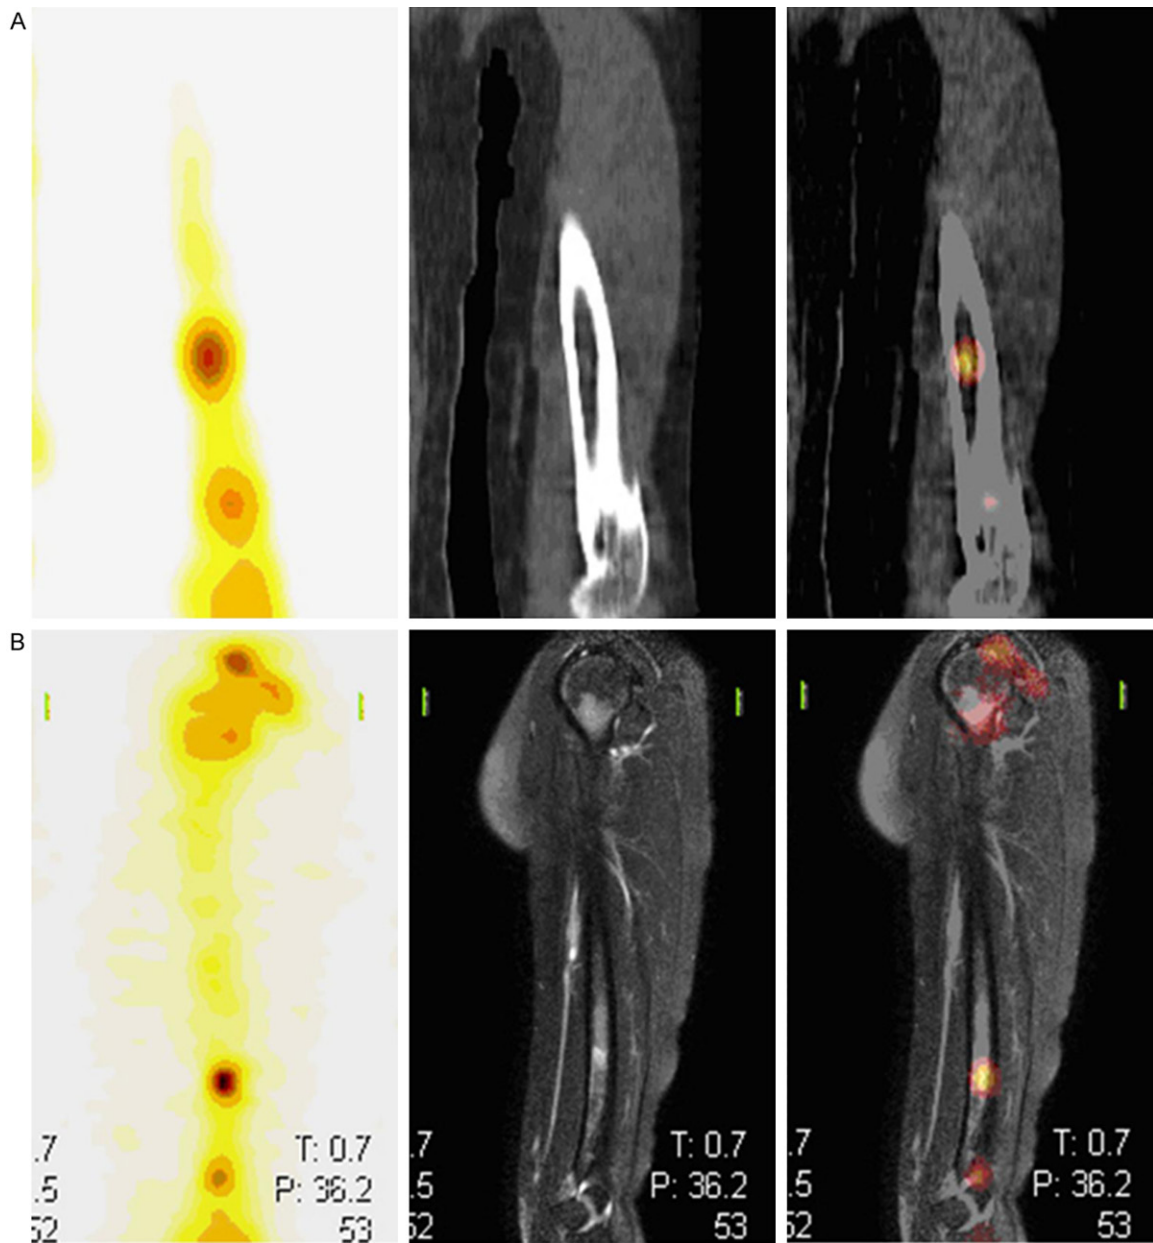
SPECT/CT and SPECT/MRI images in humerus. A. SPECT/CT image in humerus. B. SPECT/MRI image in humerus.
